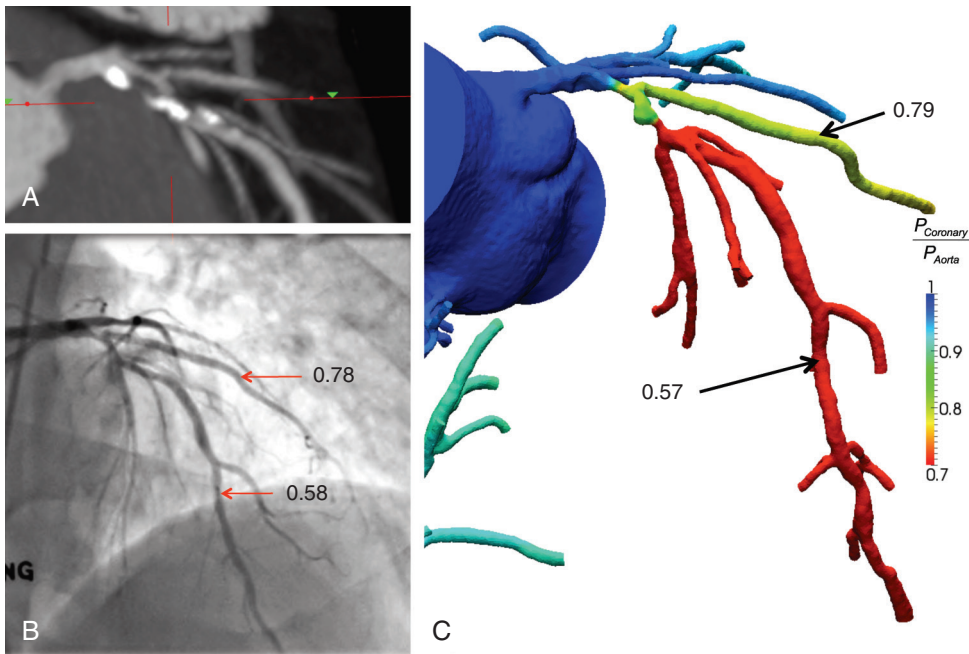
CT fractional flow reserve (FFR) using computational fluid dynamics. From the invasive coronary angiogram (A), coronary lesions assessed by invasive FFR (B) are correlated with CT-derived FFR (C). (From Nakazato R, Park HB, Berman DS, et al: Non-invasive fractional flow reserve derived from CT angiography (FFRCT) for coronary lesions of intermediate stenosis severity: Results from the DeFACTO study. *Circ Cardiovasc Imaging* 6:881, 2013.)
